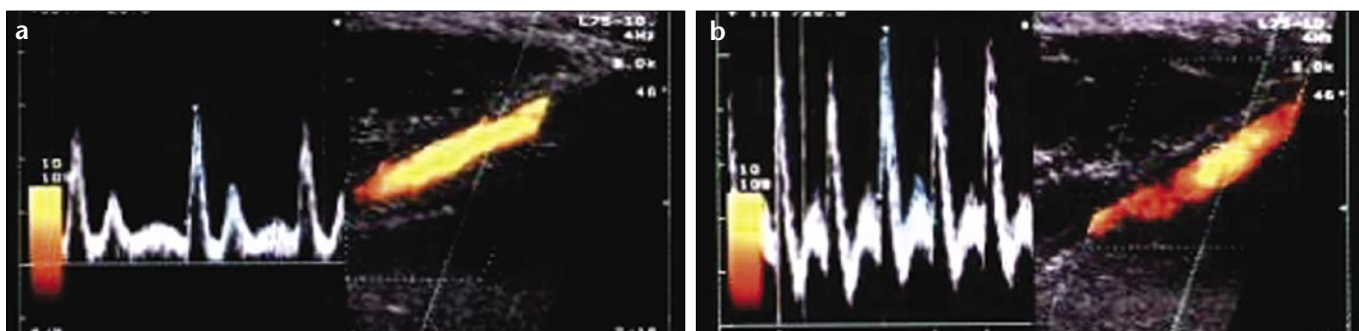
a, b. Another subject who performed incremental exercise protocol. a. Monophasic flow pattern in the power Doppler sonogram of brachial artery and normal flow pattern in spectral analysis before exercise. b. The monophasic quality of the flow pattern along with increased flow velocity and volume blood flow observed in the spectral analysis at the same level after exercise.
